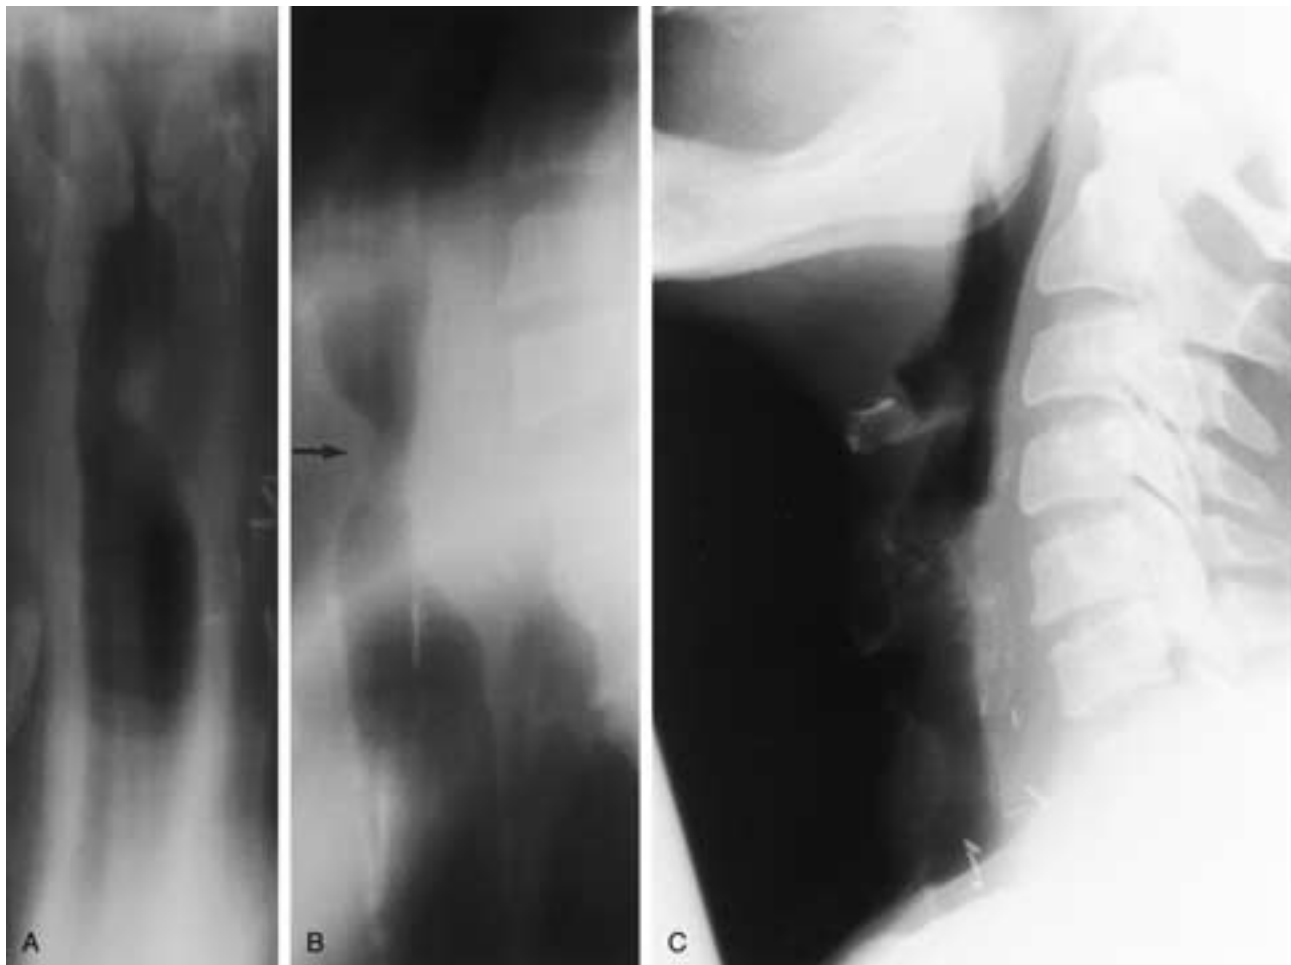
Carcinoma of the thyroid. Anterior (A) and lateral (B) conventional X-ray tomographic projections, as well as lateral plain film view of the neck (C), demonstrate a focal impression on the anterior left lateral wall of the trachea caused by an extrinsic thyroid carcinoma (B, arrow). The tracheal lumen is reduced to less than half of its normal width in the anteroposterior dimension.
